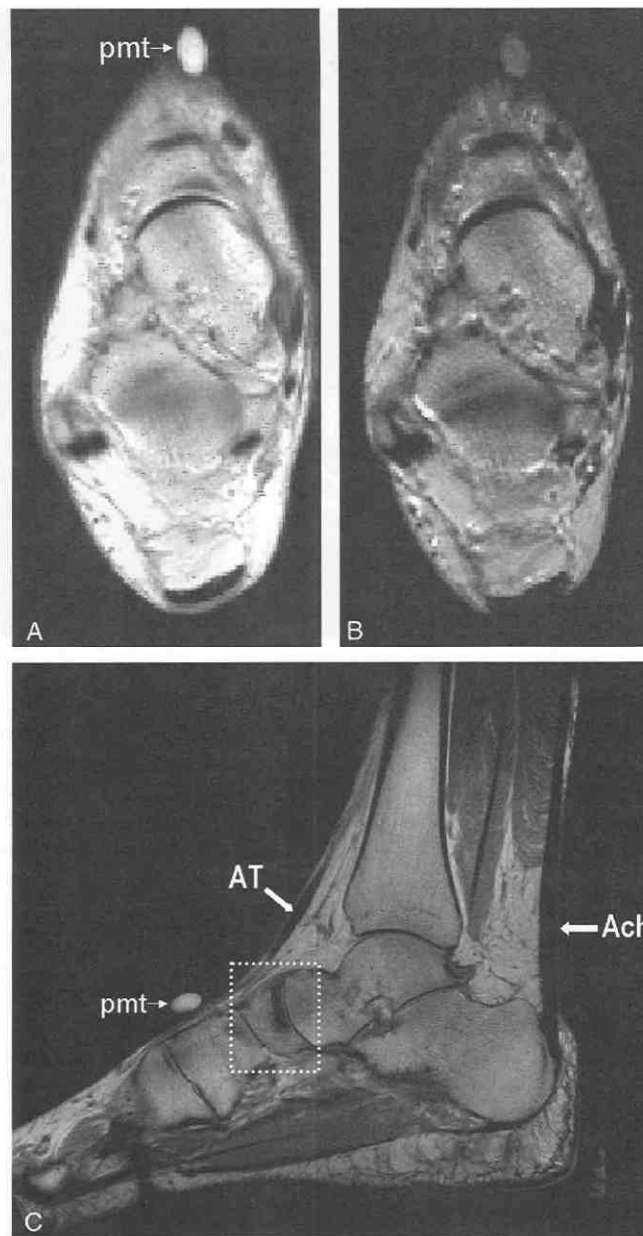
The patient is a 45-year-old woman with pain over the dorsum of the midfoot. *A* and *B*, Axial proton-density-weighted and T2-weighted images obtained through the marker indicate the point of maximum tenderness (pmt). Although this point is over the anterior ankle tendons, no edematous signal is seen within or around the tendons. *C* and *D*, Sagittal T1-weighted and fat-suppressed T2-weighted images. A portion of the normal anterior tibial tendon (AT) and the normal Achilles tendon (Ach) are seen. The *dotted square* demonstrates the unanticipated finding of a navicular stress fracture. The *dotted circle* is the normal retrocalcaneal bursa.
